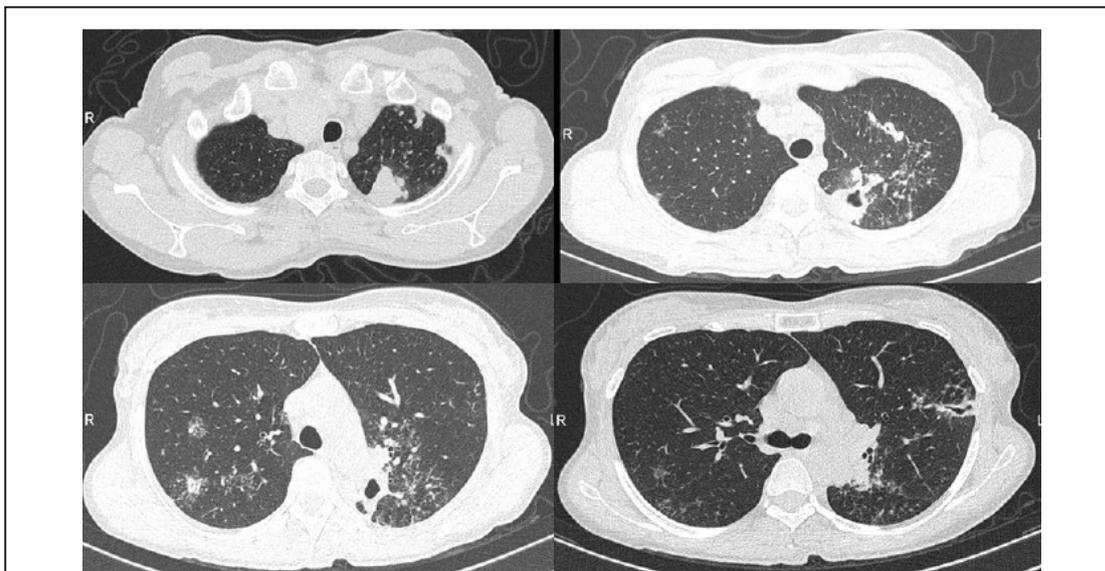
Thorax CT shows micronodules, which were common in the upper lobes, and cavitary consolidations on the left side.
